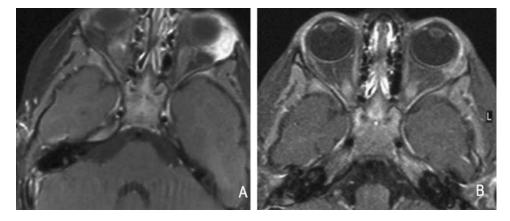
Axial T1-weighted, fat-suppressed MR images with contrast reveal an orbital tumor before chemotherapy (A) and afterward (B). The tumor, which was proven to be an alveolar rhabdomyosarcoma, shows marked reduction of enhancement after therapy.
